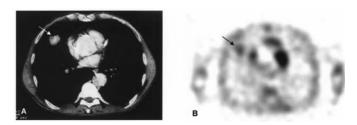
A 70-year-old male patient with a 25-mm squamous cell carcinoma in the lower lobe of the right lung which appeared as an SPN at CT (A, arrow). A focal area of increased <sup>99m</sup>Tc-tetrofosmin uptake, with a T/N value of 2.9, was evidenced at transaxial SPECT (B, arrow), corresponding to the carcinoma.
